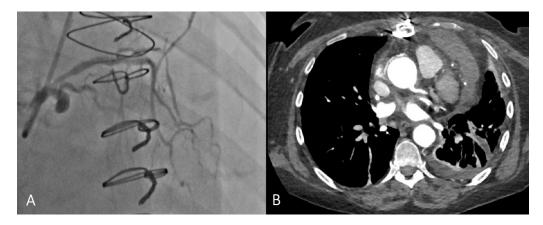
(A) Completion coronary angiogram demonstrating exclusion of the pseudoaneurysm with a covered stent. (B) CTA image obtained four weeks after stent placement demonstrating postsurgical changes and no filling of the pseudoaneurysm.
